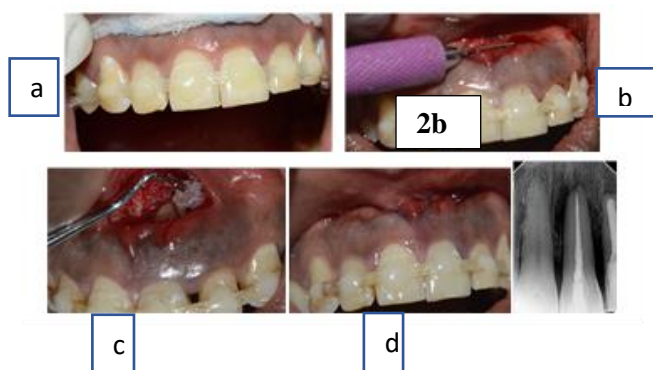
2: Fig 2a: splinting in relation to 13 to 23 with interlig, Fig 2b: Horizontal incision at the mucosa, Fig 2c: Placement of bone graft, Fig 2d: suturing done, Fig 2e: Immediate postoperative radiograph.
